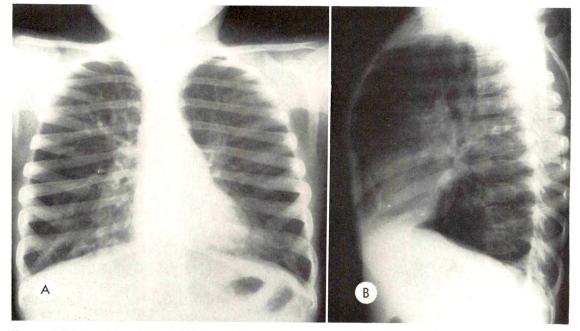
(A) Posteroanterior and (B) lateral chest roentgenograms of a white female, aged 5 years, show evidence of pulmonary emphysema, with considerable parenchymal streakings, and of impairment of alveolar pneumatization. The anteroposterior diameter of the thorax is increased above normal, the sternum is bulging, the clavicles are elevated, and the diaphragm is flattened.
